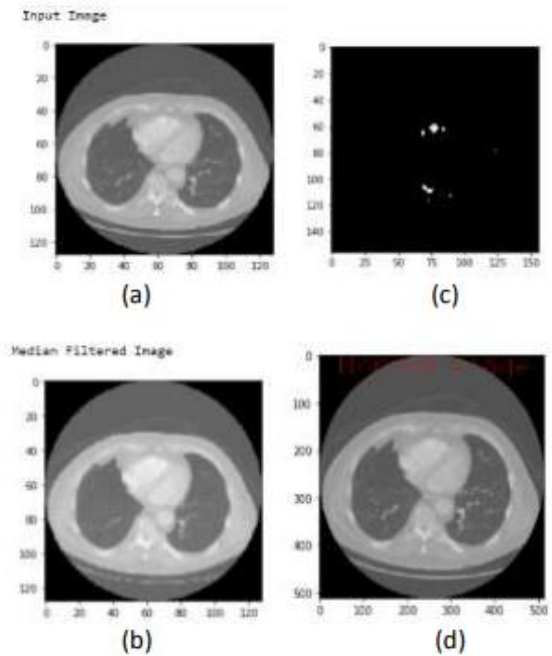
Lung cancer CT scans (a) Input image, (b) Median filtered image, (c) Nodules representation, (d) Detection of nodule as normal nodules
